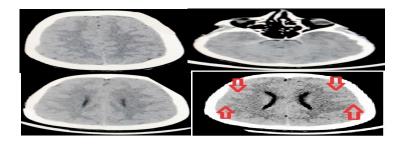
Non contrast Computed Tomography(CT) scan appear non-specific oedema (Red arrow)
